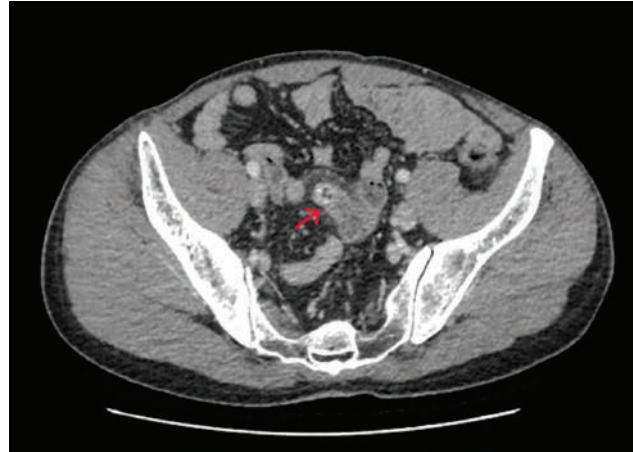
Abdominal CT scan. An intestinal loop with a blind end is observed, thought to originate from ileal loops. Inflammatory changes in the surrounding adipose tissue are also of note. Laparoscopic exploration images.
